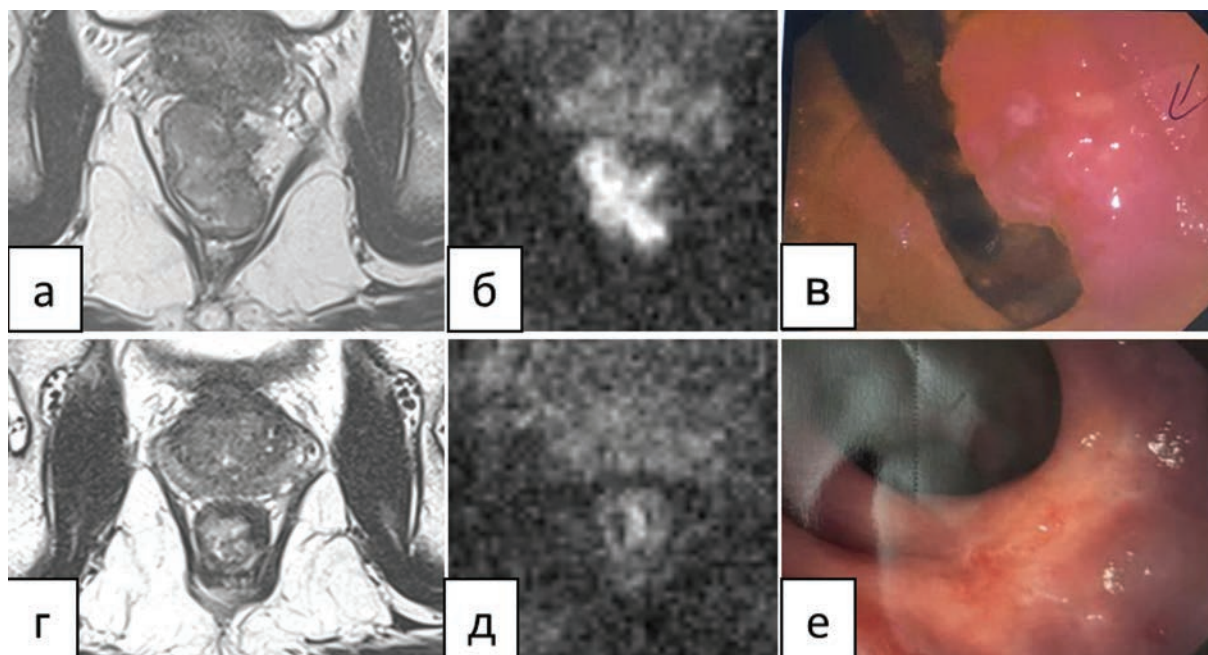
MRI of a cCR in a 38-year-old patient with an initial mucinous tumor of the lower rectum T2 to T2VI (a); 25 weeks after the end of the CT scan, a full-layered fibrous scar with small inclusions of mucin (b) and a flat white scar (B). The arrows indicate the tumor and the scar
